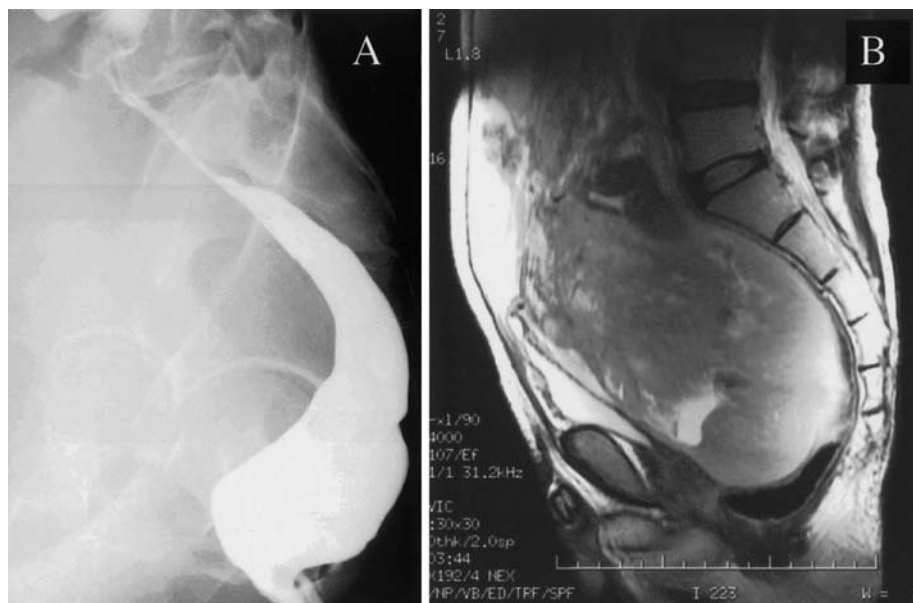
A The barium-filled rectum gradually tapers to a narrow lumen. No irregular mucosal pattern and no barium-filled tumor cavities are recognized. B Magnetic resonance imaging (T2-weighted image) reveals a large tumor that shows a non-homogeneous structure and displaces the rectum
